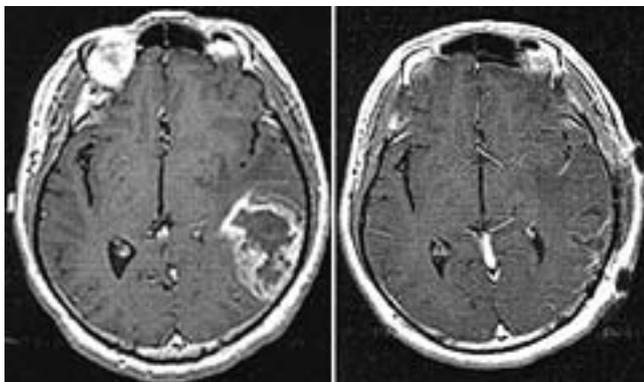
Gadolinium-enhanced MR images obtained before (*left*) and 24 hours after surgery (*right*) in a 55-year-old man who presented with progressive receptive dysphasia. The large left temporal GBM was successfully resected using frameless image guidance. Postoperatively the patient experienced significant improvement of his symptoms.
